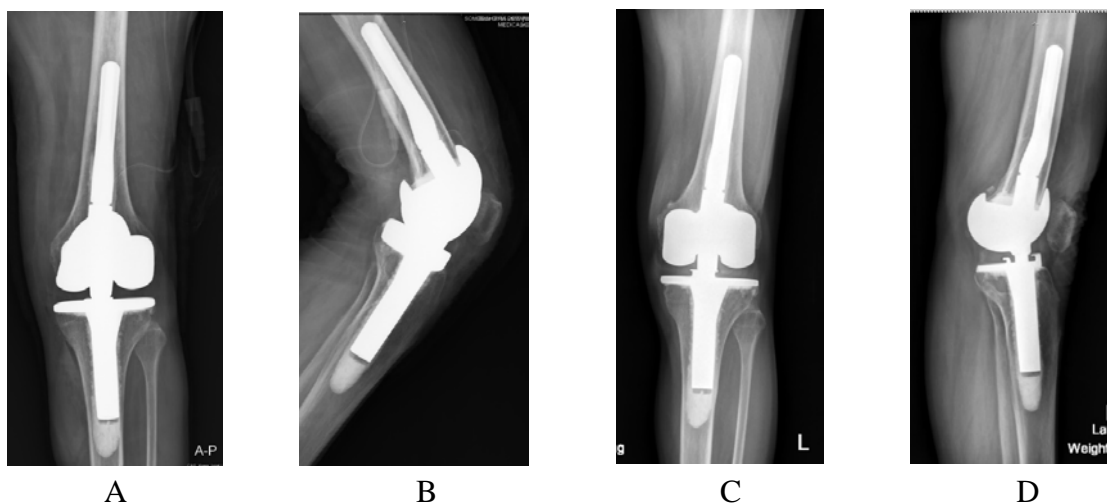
A, B show the immediate post-operative x-ray and C, D were the 18-month radiographic evaluation. There was a non-progressive sclerotic line at tip of femoral stem. Neither implant malposition nor abnormal radiolucency line between cement-prosthesis interface were observed.
